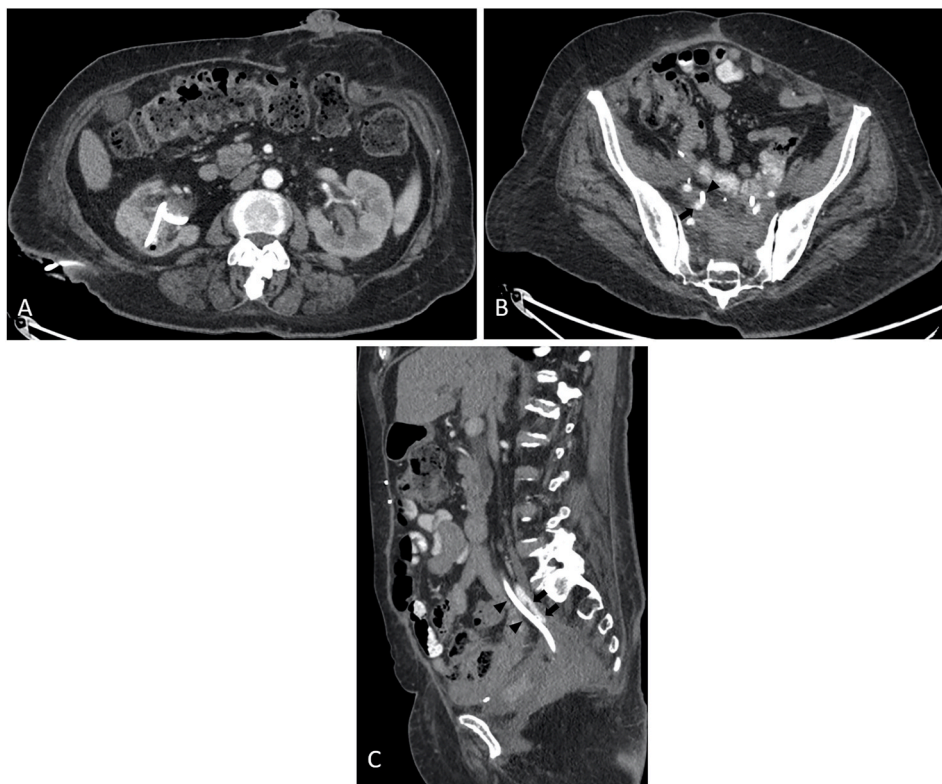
(A) Axial cut arterial phase CT angiogram of the abdomen and pelvis shows the right nephro-uretral catheter proximal pigtail within the renal pelvis, no evidence of contrast extravasation or vascular injury. (B,C) Axial and sagittal cuts arterial phase CT angiogram of the abdomen and pelvis shows the right Nephro-uretral catheter (Arrowheads) coursing in close proximity to the right internal iliac artery (Arrows).
